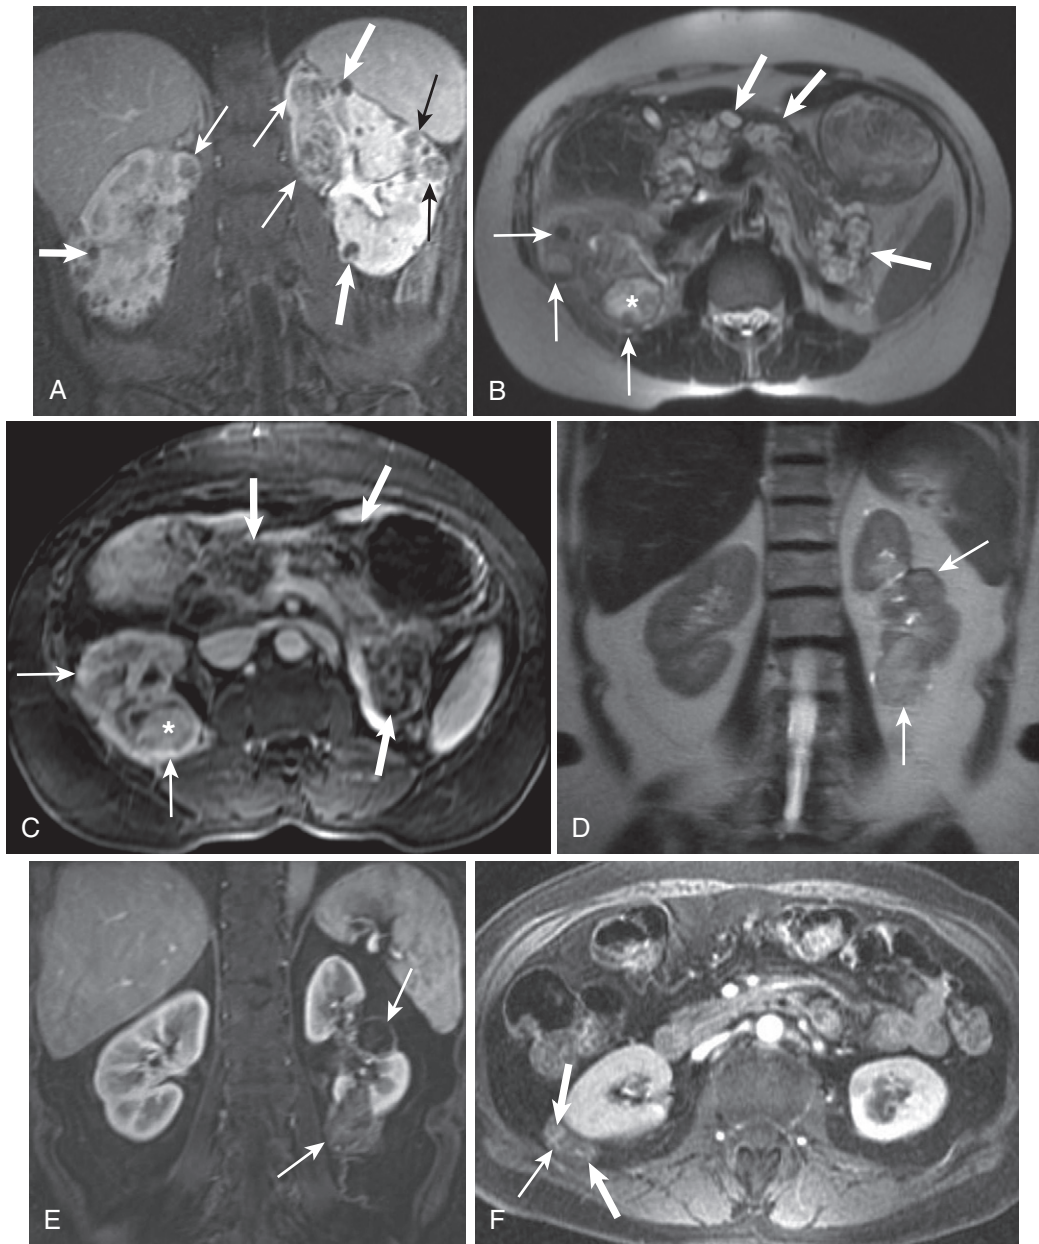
VHL and TS. A, The coronal postcontrast image in a patient with VHL disease shows multiple bilateral enhancing (*thin arrows*) and nonenhancing cystic lesions (*thick arrows*). Axial T2-weighted (B) and enhanced (C) images in a different patient with VHL reveal complex cystic lesions (*thin arrows*) in the right kidney (post left nephrectomy), including a cystic RCC (*asterisk*), and multiple complex cystic pancreatic lesions (*thick arrows*). Two heterogeneous noncystic left renal lesions (*arrows*) on the coronal T2-weighted image (D) in a different patient with TS fail to yield signal on the fat-suppressed image (E), and the corresponding fat-suppressed axial image (F) shows a similar lesion in the right kidney (*arrows* in E and F) with eccentric vascular enhancement (*thick arrows* in F)—all consistent with AMLs.
